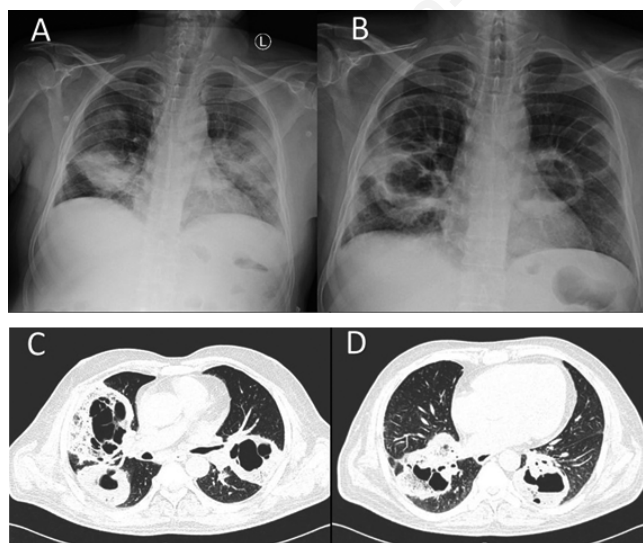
A,B) Chest roentgenograph at admission and 8 days later; C,D) computed tomography thorax showing bilateral cavities with peri-cavitory consolidation.
